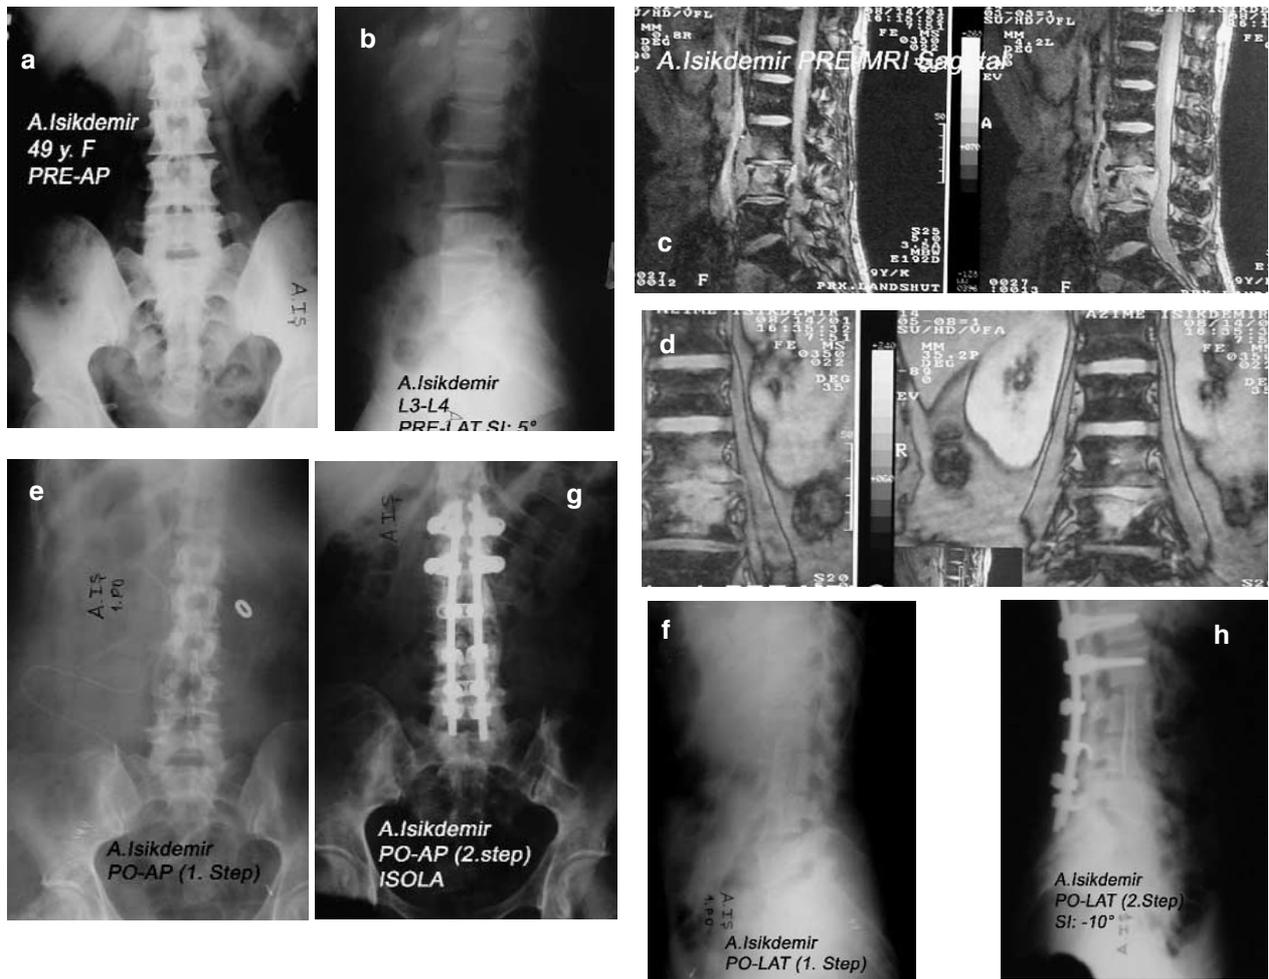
Preoperative A-P (a), letaral (b) graphies, sagittal and frontal (c) MR images of the patient treated with combined surgery and posterior isola instrumentation. After first step operation AP (c) and lateral (f) and after second step operation AP (g) and lateral (h) graphies of the patient.
